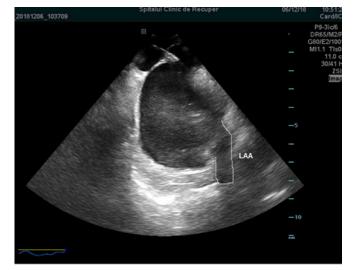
Intracardiac echocardiography to guide transseptal puncture. From the "septal view" a counter clockwise rotation of the probe will bring the left atrial appendage into image.
